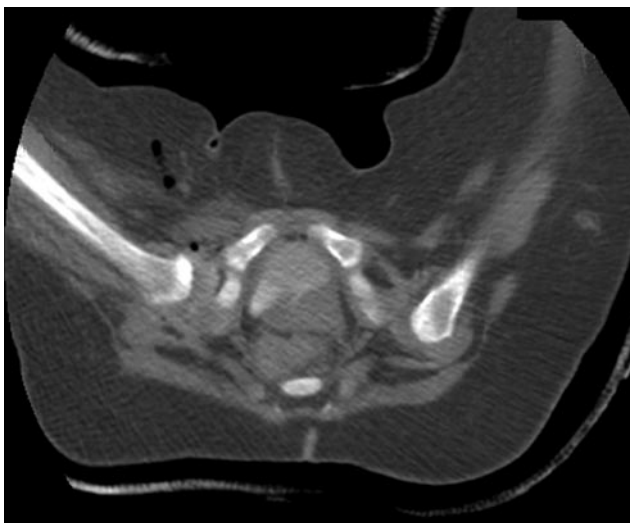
Computed tomography scan after initial surgery on right hip shows reduced right hip and unreduced left hip.
